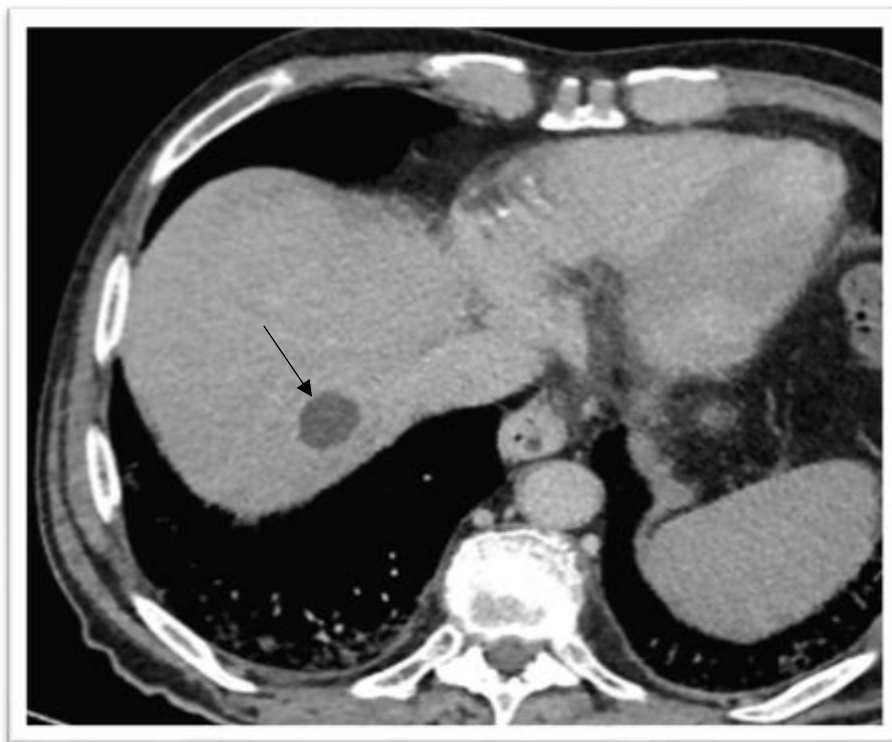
pre-cTACE CT-scan during arterial phase (a). The same nodule on DSA during c-TACE (b).
